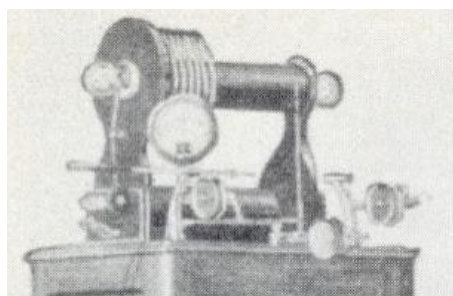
Component of a "therapeutic" X-ray unit. Ca. 1914, the use of X-rays in combination with high-frequency current was being considered e.g. for periodontal treatment [52]. The application of this technique was short-lived.
